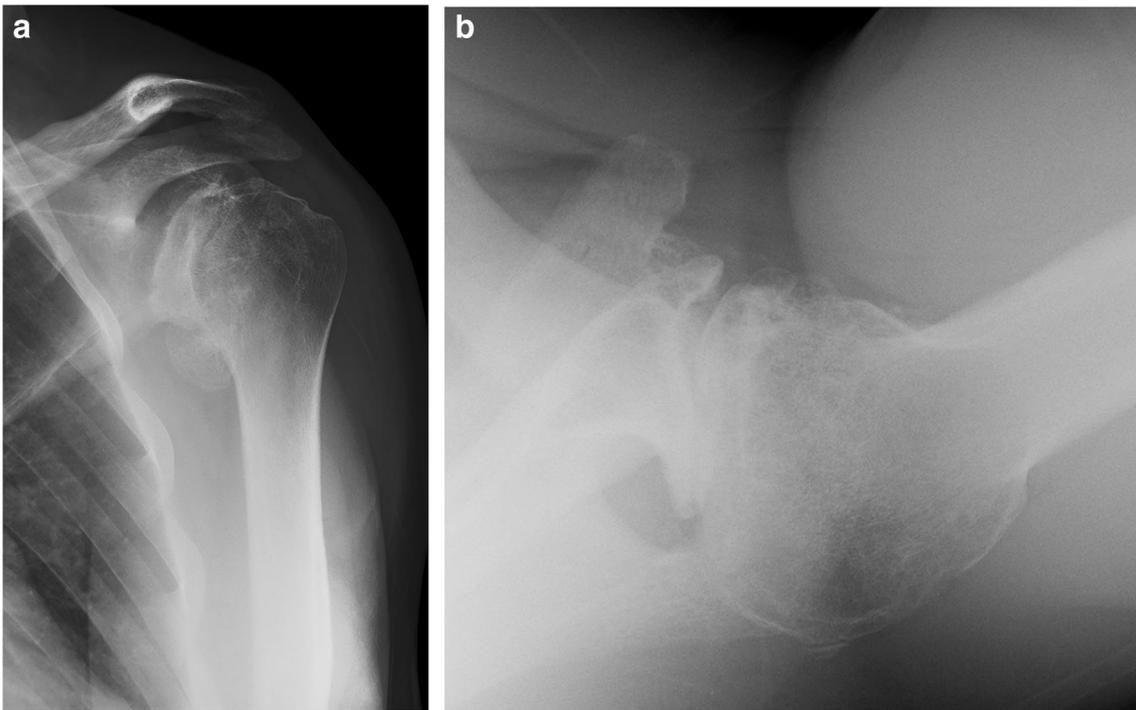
Case 2. a Pre-operative AP and b axillary radiographs showing severe degenerative joint disease and a type B2 glenoid with biconcavity and posterior decentering of the head on the glenoid
